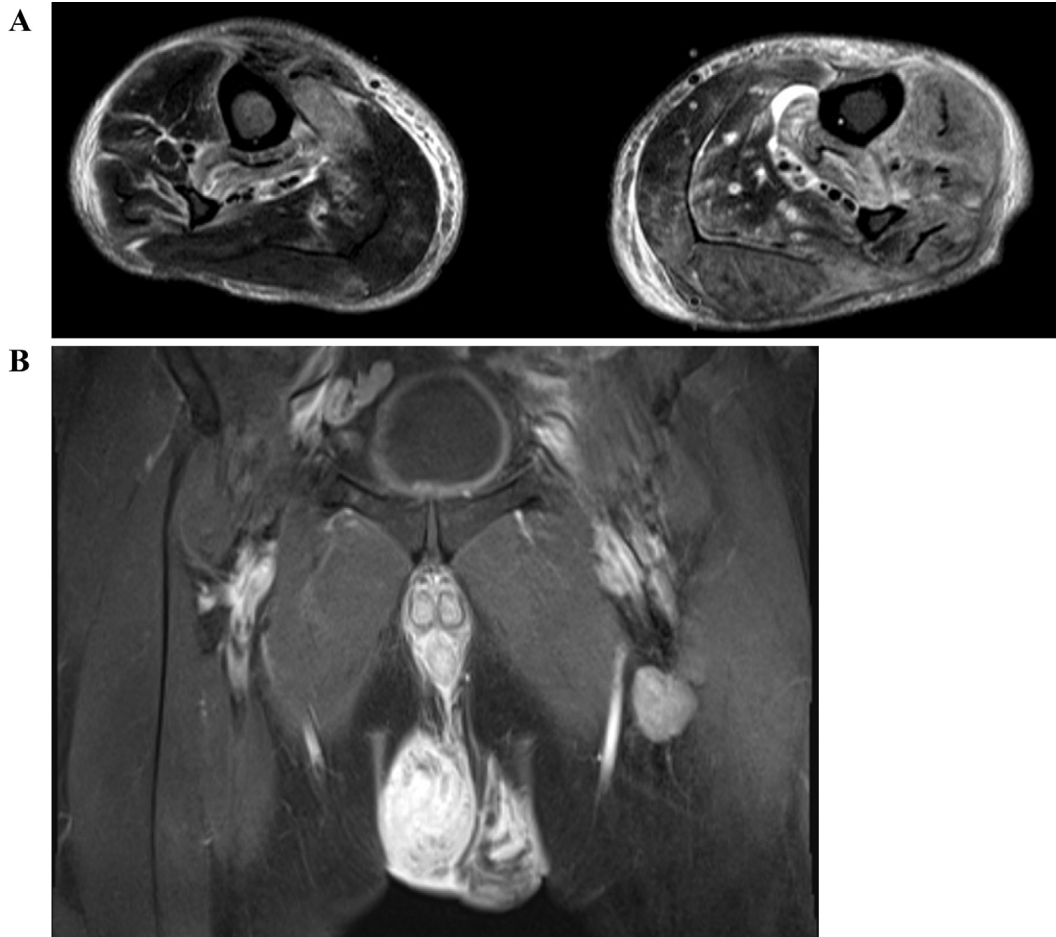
Magnetic resonance imaging. A: Axial short-TI inversion recovery (lower legs). B: Coronal T1 (testicles).
